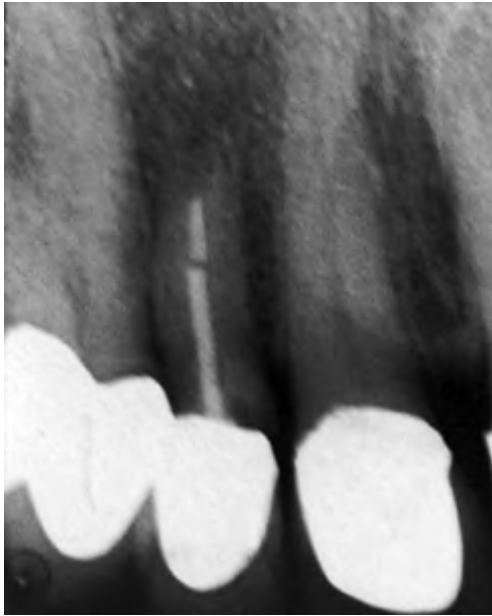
Preoperative periapical radiograph of the maxillary right lateral incisor prior to extraction. There was a horizontal root fracture approximately in the middle third of the root.
